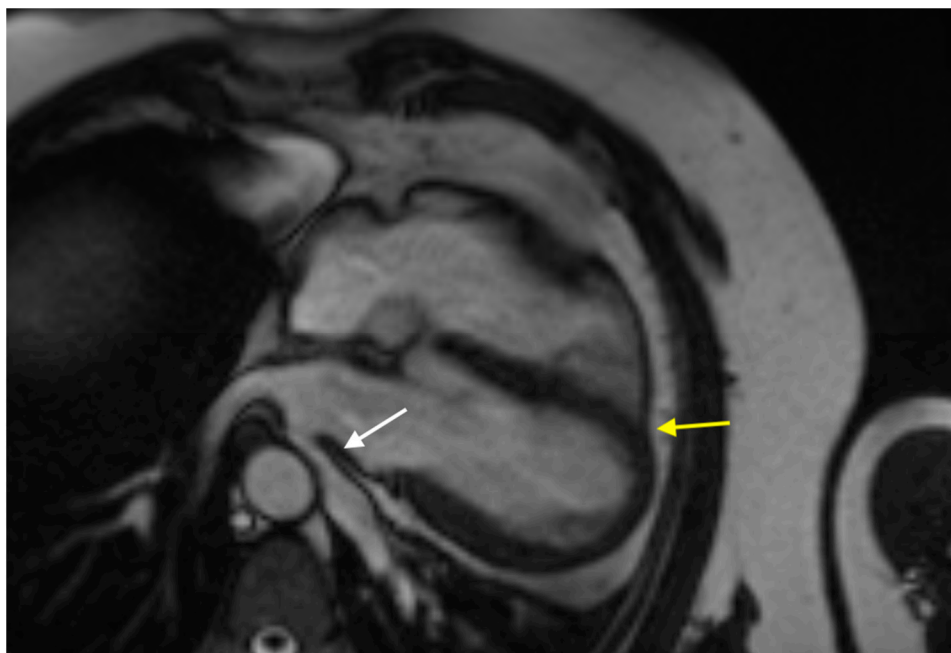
Cardiac magnetic resonance imaging (MRI) in the four-chamber cine view, confirming abnormal cardiac position with pronounced levorotation (yellow arrow). The inferior pulmonary vein is compressed between the descending aorta and the left atrium, likely as a consequence of the altered cardiac orientation (white arrow).
